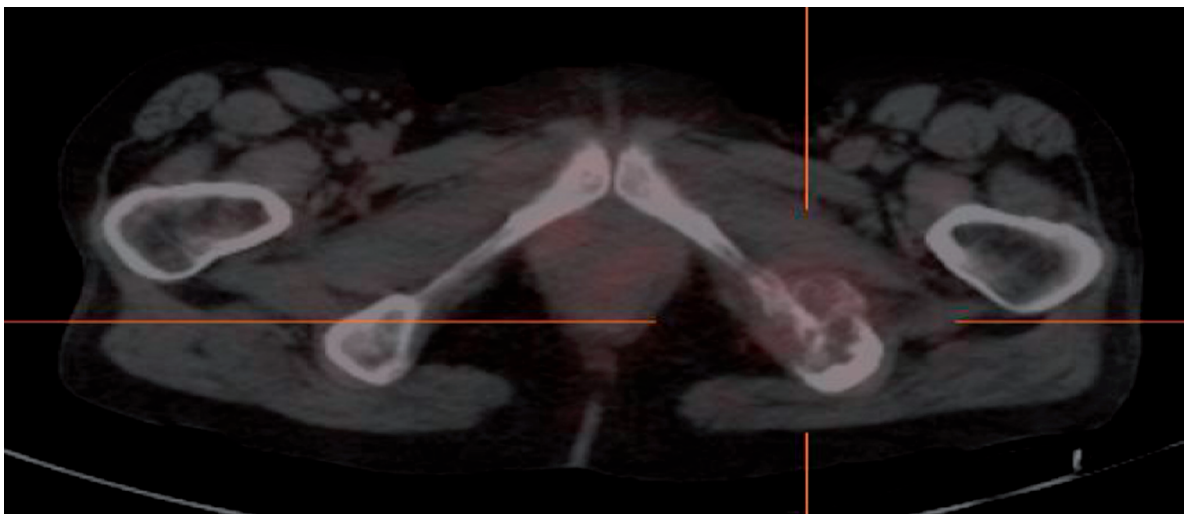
A  $^{111}\text{In}$ -octreotide SPECT/CT in Case 3 patient, after two courses of sunitinib treatment, showing clear regression of  $^{111}\text{In}$ -octreotide uptake in osseous lesion, and corresponding to PR of disease.
